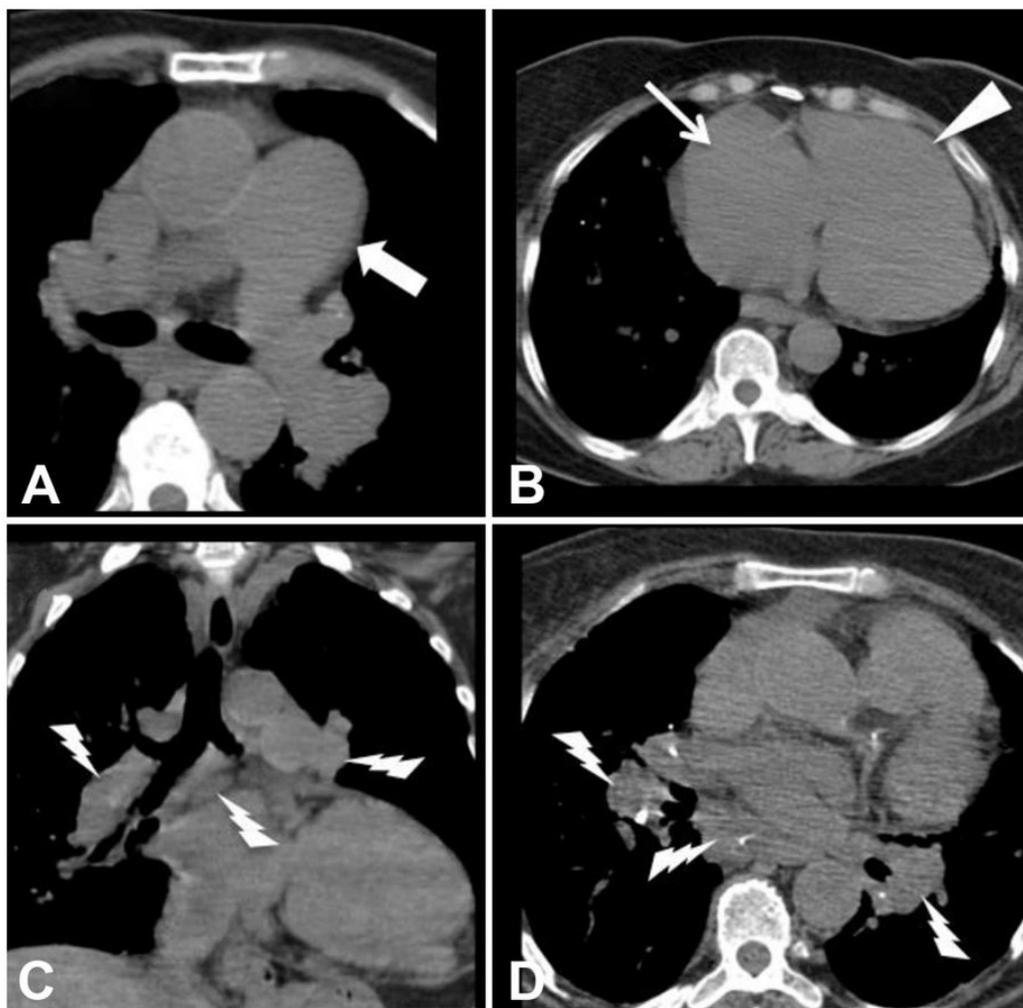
Imaging findings associated with PCH, as seen on non-contrasted chest CT in soft tissue windows. A and B – axial views demonstrate evidence of significant pulmonary hypertension manifested by enlargement of the main pulmonary artery (thick white arrow) which measured 3.6 cm, as well as marked enlargement of the right atrium (thin white arrow) and right ventricle (white arrowhead); C (coronal view) and D (axial view) show the enlarged mediastinal and hilar lymph nodes, nonspecific, but which in the setting of pulmonary hypertension can be associated with PCH.
